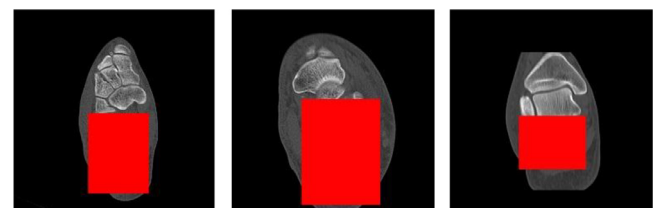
Pre-processing results from fractured calcaneus CT images. (For interpretation of the references to color in this figure legend, the reader is referred to the web version of this article.)
